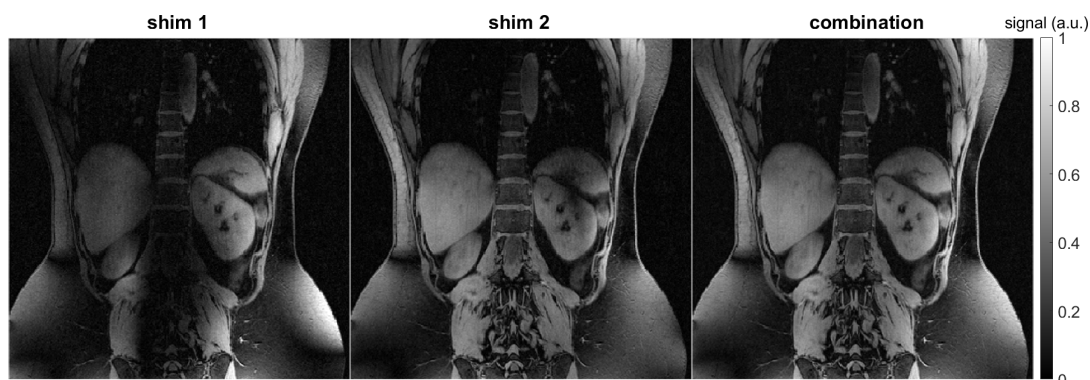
Coronal view of the same slice for the two acquired TIAMO shim modes and the combined ^1H MR image. The signal dropouts in different regions for the two shims reduces the signal dropout severity in the combined image as can for example be observed in the left kidney for the here shown slice.
